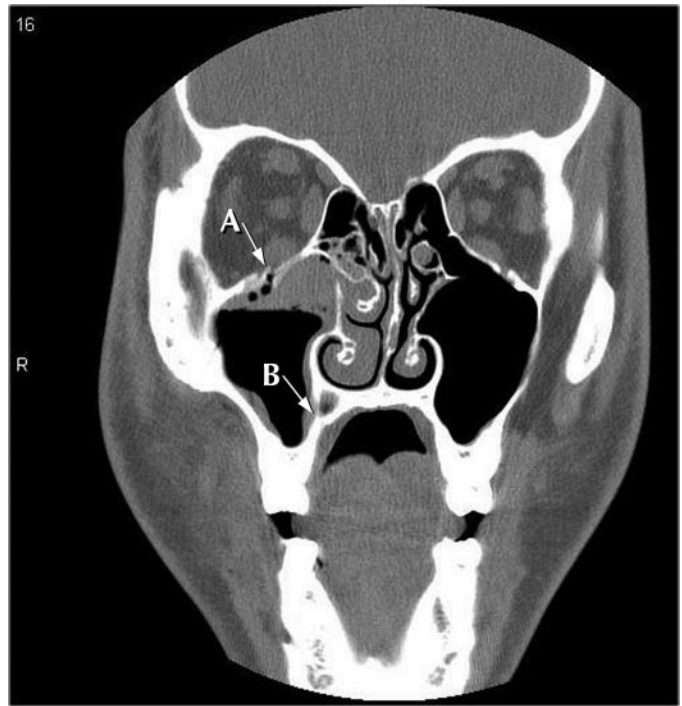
Coronal computed tomography image of right orbital floor fracture with small fragment extending into the right maxillary sinus (A) and medial wall fracture of the right maxillary sinus (B).
